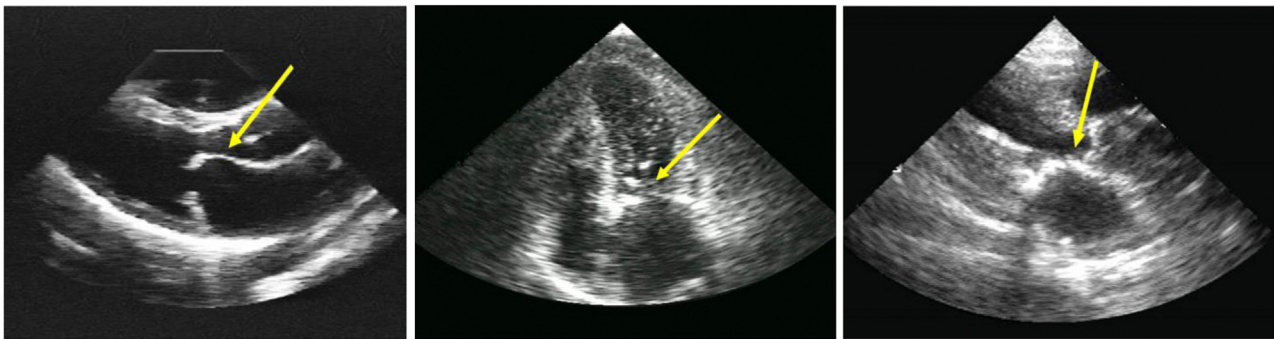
Image at left is parasternal long axis view of a patient with classic hockey stick deformity of the anterior mitral valve leaflet (arrow) and restricted mobility of the posterior leaflet. Center and right: apical and parasternal long axis views showing severe leaflet and annular calcification, respectively (arrows) in a 42-year-old patient with renal failure on dialysis. No rheumatic deformity is seen.
